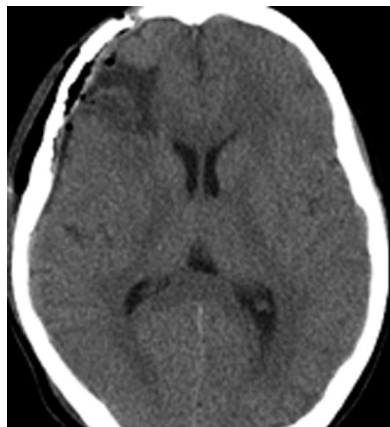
Postoperative brain computed tomography: no procedural complications.
